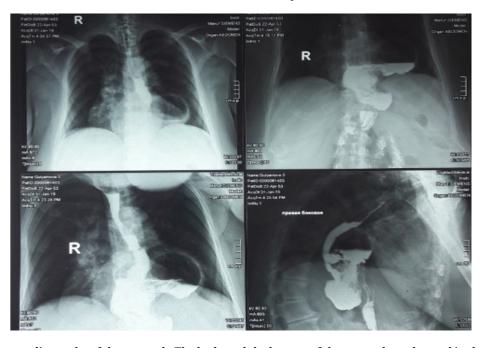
Contrast radiography of the stomach. The body and the bottom of the stomach are located in the chest cavity.
